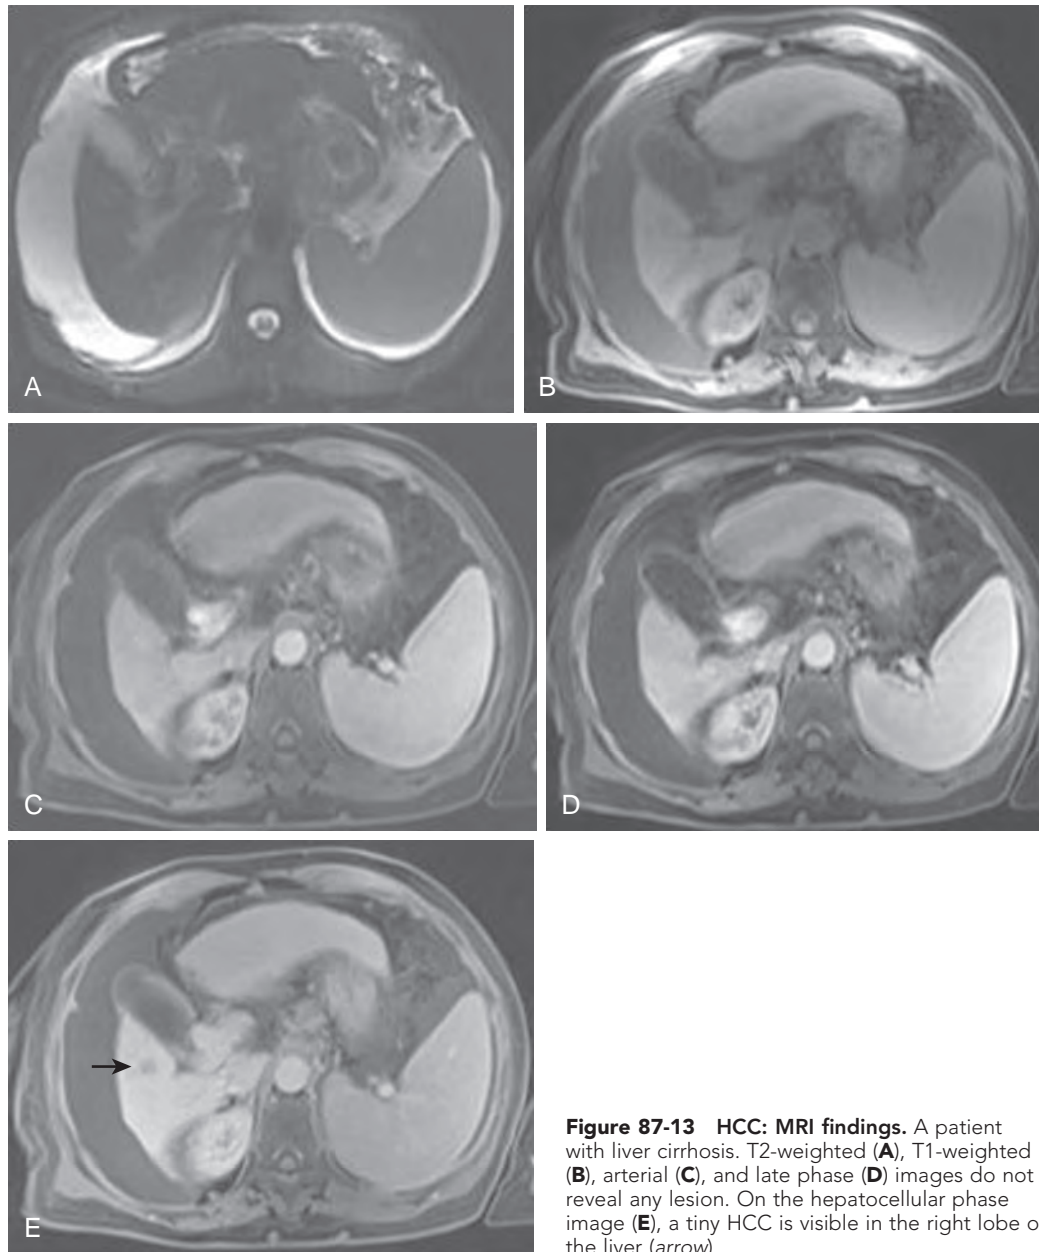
HCC: MRI findings. A patient with liver cirrhosis. T2-weighted (A), T1-weighted (B), arterial (C), and late phase (D) images do not reveal any lesion. On the hepatocellular phase image (E), a tiny HCC is visible in the right lobe of the liver (arrow).
